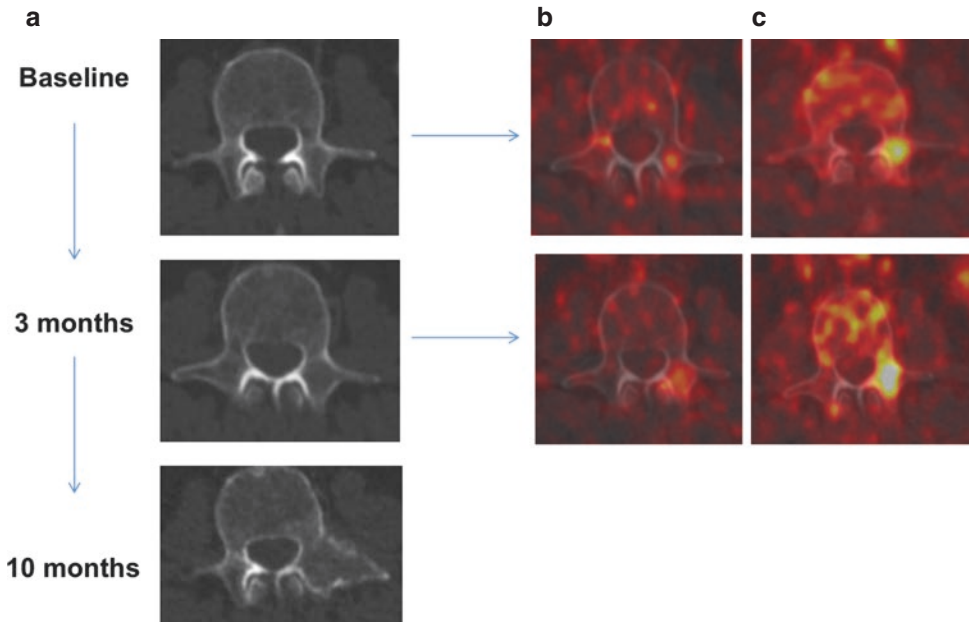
More than one radiopharmaceutical may be helpful to assess therapy response in oncology. Change in radiopharmaceutical uptake is more pronounced on the ^{18}F -FDG PET/CT than on ^{18}F -DCFPyL PET/CT at a site
